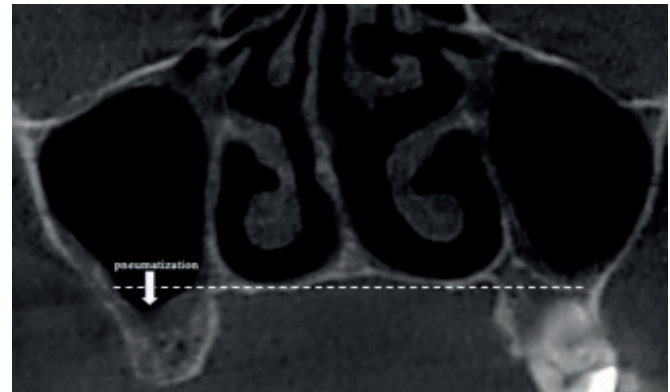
CBCT coronal section showing maxillary sinus pneumatization
